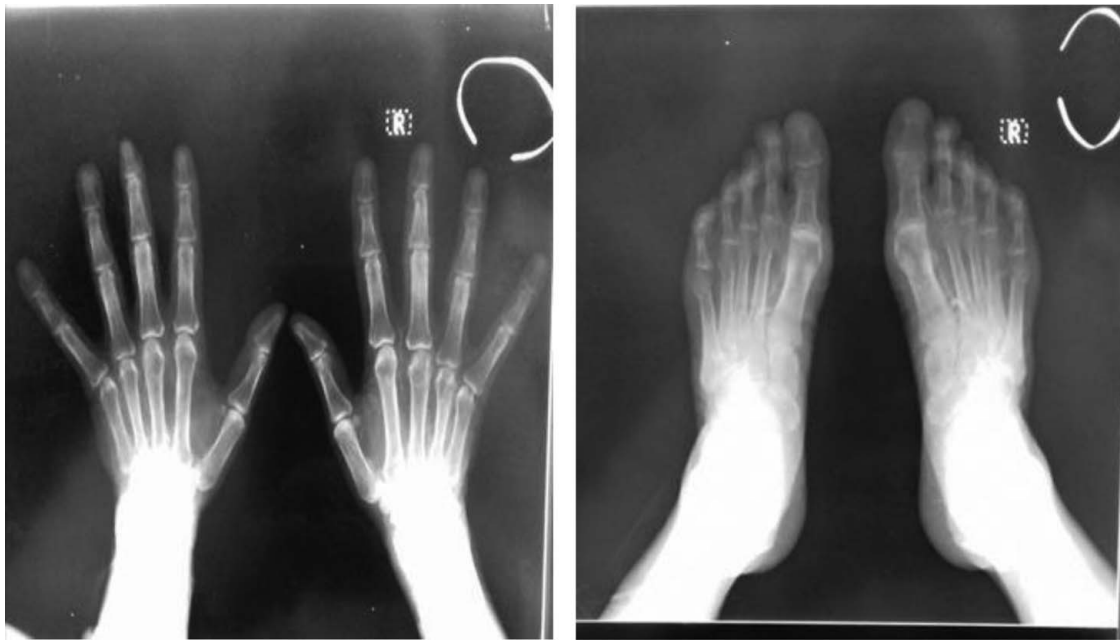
An radiograph of hands and feet revealed calcifications.
